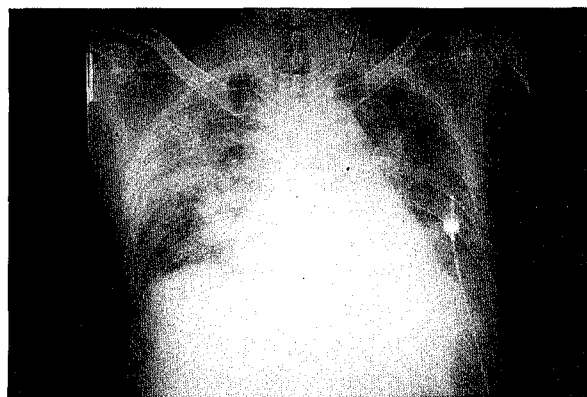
A radiograph of the chest showed air-space disease involving the bilateral lungs.
